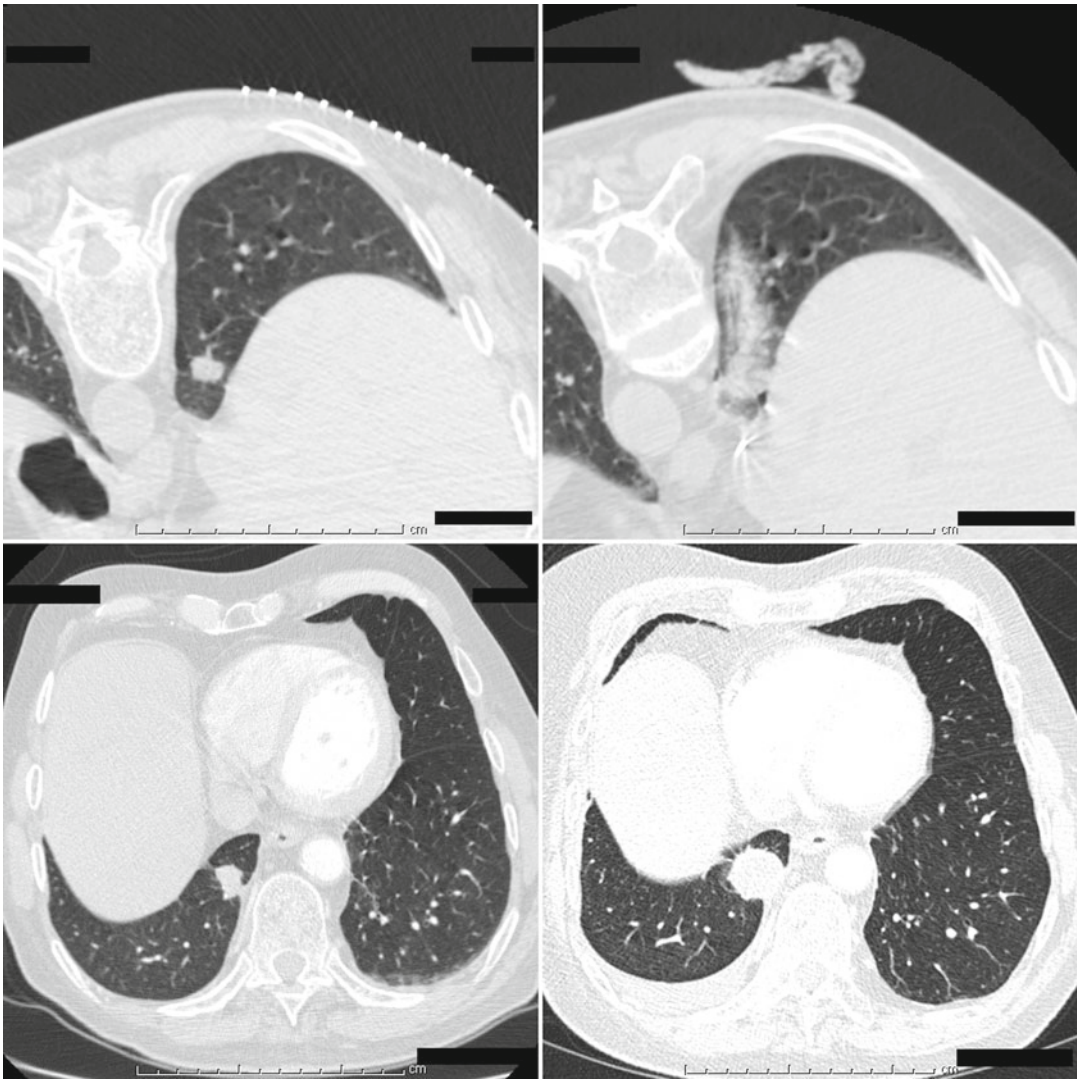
Local recurrence after RFA. A NSCLC is visible in the lower lobe of the right lung on a localizing CT image, just before RFA (*upper left*). Immediately after RFA the lesion is obscured by thermal injury and hemorrhage (*upper right*). Three months later a contrast-enhanced CT shows
